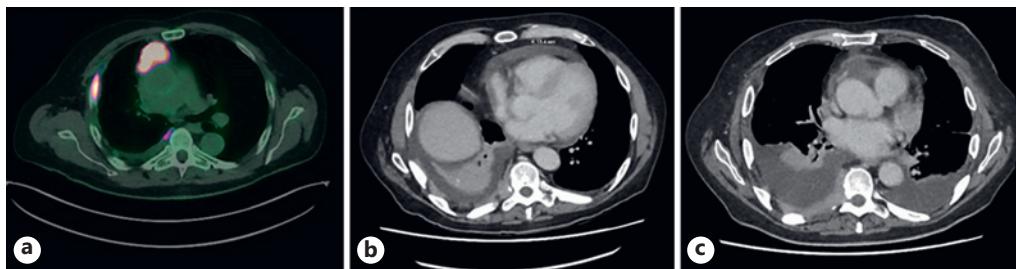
Imaging series of thymic carcinoma, pericardial effusion, and pleural effusions. a Axial PET CT showing anterior mediastinal mass and right pleural disease. b Axial CT upper abdomen showing 15.4 mm pericardial effusion. c Axial CT upper abdomen showing bilateral pleural effusions.
